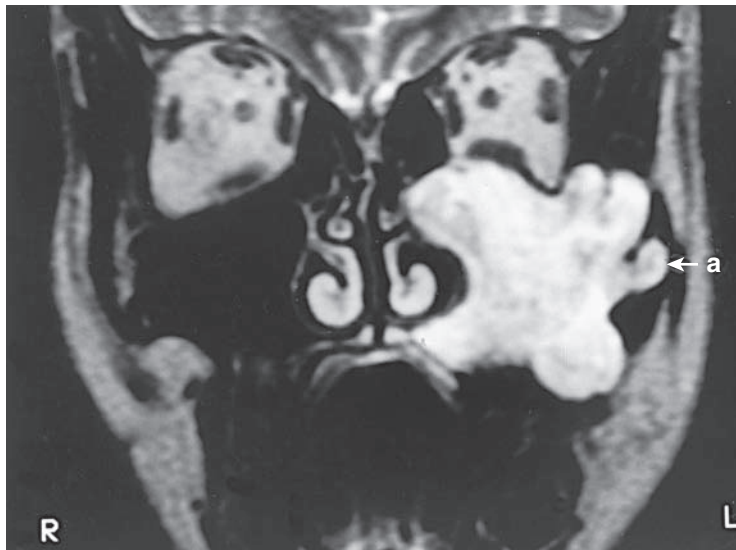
Coronal magnetic resonance image (MRI) showing infiltrative lobularity by an odontogenic keratocyst. (Image kindly provided by Professor L.J. van Rensburg and previously published in *Oral and Maxillofacial Clinics of North America*, Vol. 15(3): 363–382 by van Rensburg, L.J., *et al.* Correlative MRI and CT imaging of the odontogenic keratocyst: a review of twenty-one cases. Elsevier Publishers, 2003, with permission.)
